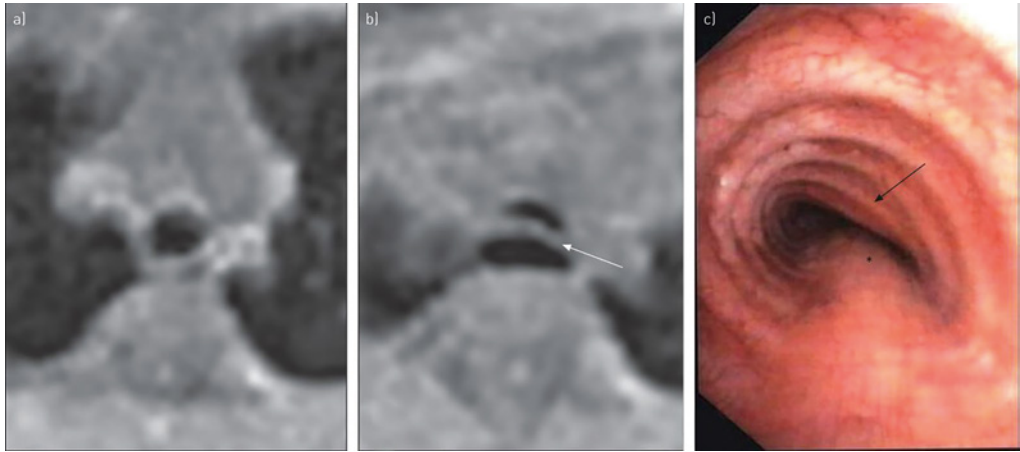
Axial reformatted images of patient F. (a) Breath-hold magnetic resonance image at end inspiration showing a normal round configuration of the trachea. (b) Breath-hold at end expiration at the same level, note that the pars membranacea is bulging into the lumen (white arrow). (c) Shows the same location as a) and b) during bronchoscopy evaluation during tidal volume breathing, which confirms tracheomalacia caused by an abnormal configuration of cartilage rings (black arrow) combined with bulging of the pars membranacea (*).
